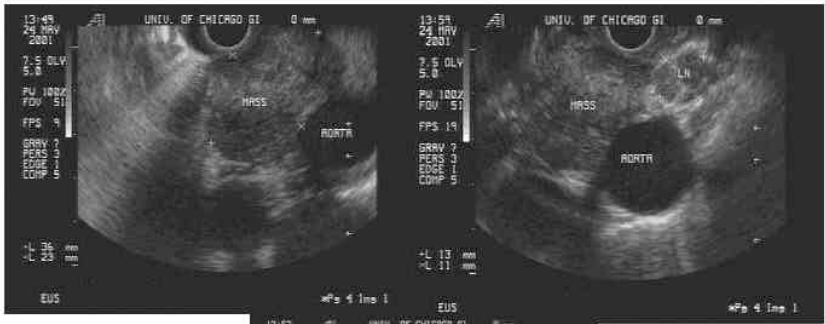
Endosonographic image of a mediastinal mass undergoing fine-needle aspiration guided by endoscopic ultrasound. Pathology reveals non-small cell lung cancer.
